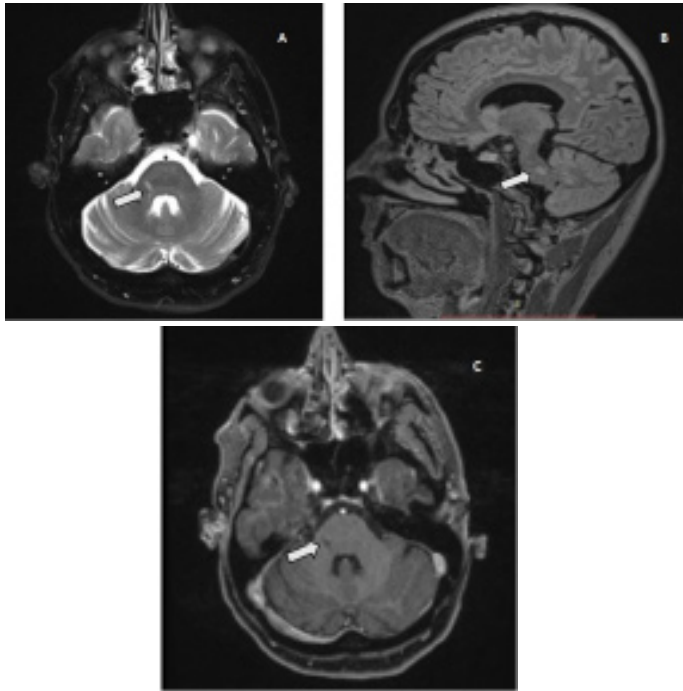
MRI of patient presenting trigeminal neuralgia secondary to MS. (A) Axial T2; (B) Sagittal T2 FLAIR; (C) Axial T1. Arrows point to the demyelinated lesion.
